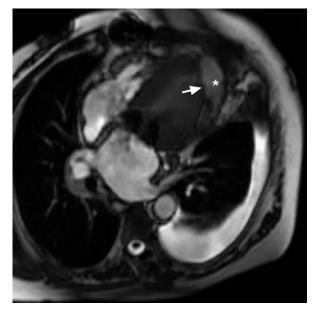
Magnetic resonance image shows the defect in the apical neck (arrow) and the larger pseudoaneurysmal sac (asterisk).
